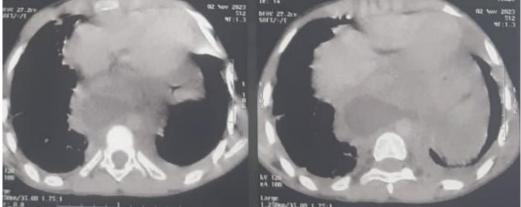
Thoracic CT scan showing a mediastinal mass
